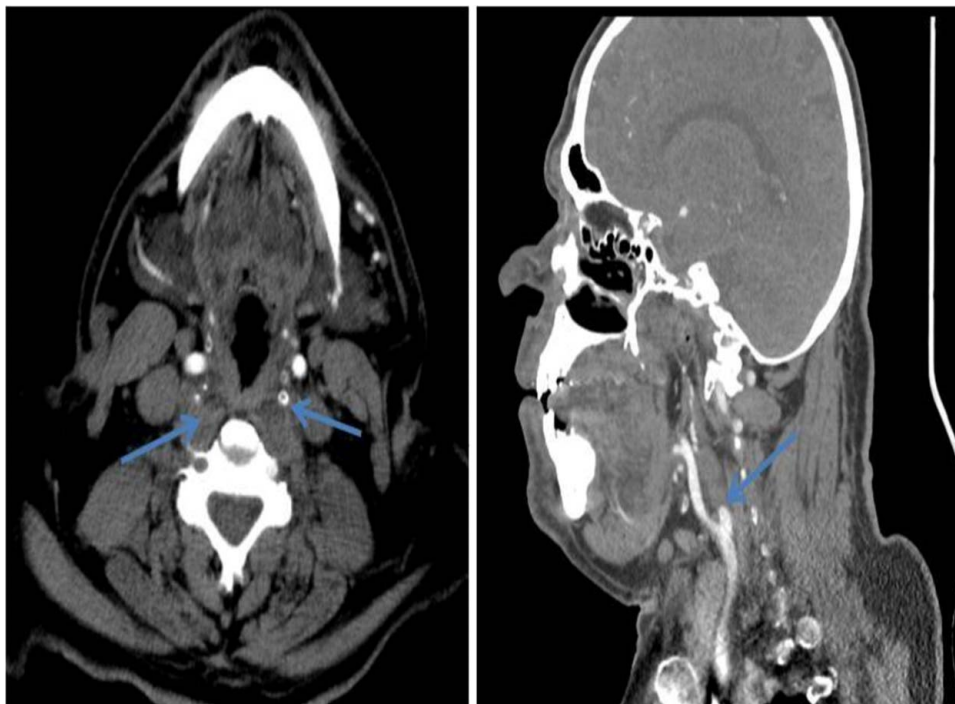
Axial and sagittal views of neck computed tomography angiography show occlusion in both internal carotid arteries (ICAs).
